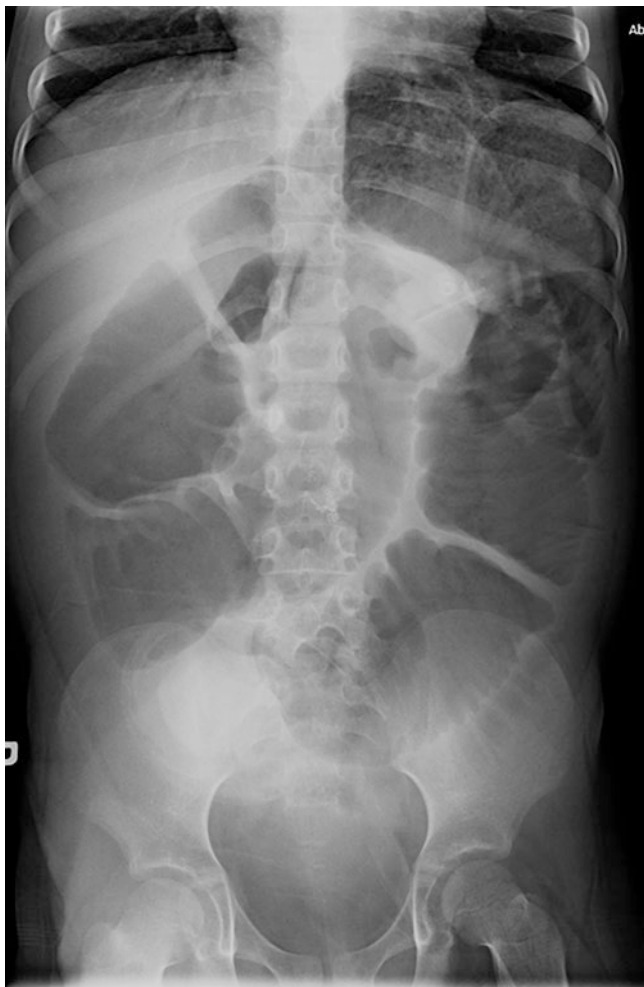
Plain abdominal X-ray in a 7-year-old girl with PIPO. Note the enlarged and hugely dilated small bowel loops
